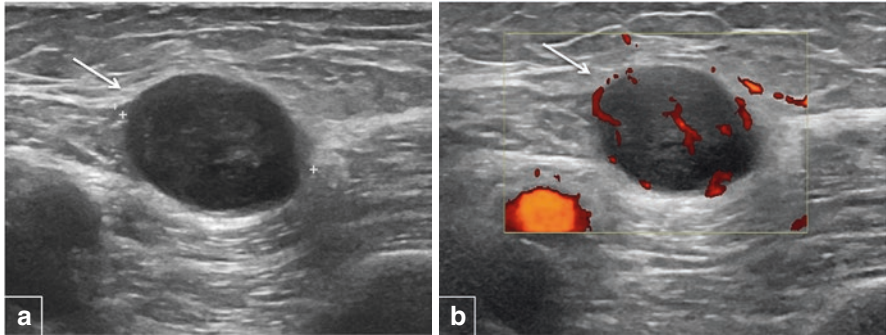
US image demonstrating a heterogenous, predominately hypoechoic lesion (a) (arrow) with increased vascularity on power Doppler (b) (see US applications below). Biopsy confirmed a soft tissue sarcoma
